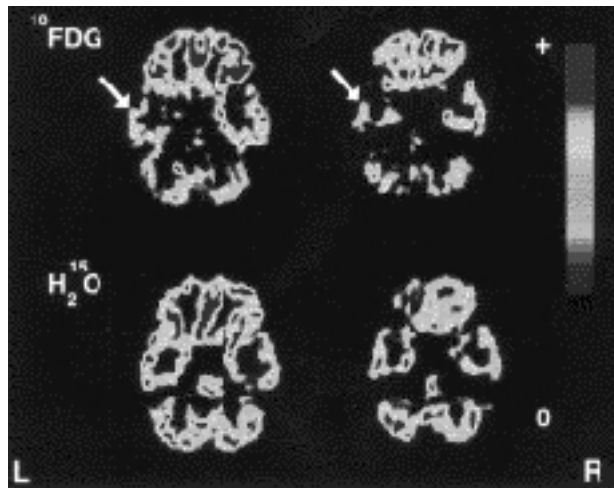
Upper arrows indicate left temporal lobe hypometabolism. Lower row demonstrates postictal persistent hyperperfusion of the same epileptic temporal lobe evidenced by elevated NRV's (1.05). Asymmetry indices were reversed. (FAI for FDG : -8.9, blood flow : +6.81). The patient's last clinical seizure was 24 hours prior to PET scan. The patient underwent left temporal lobectomy based on the ictal EEG and FDG-PET results.
